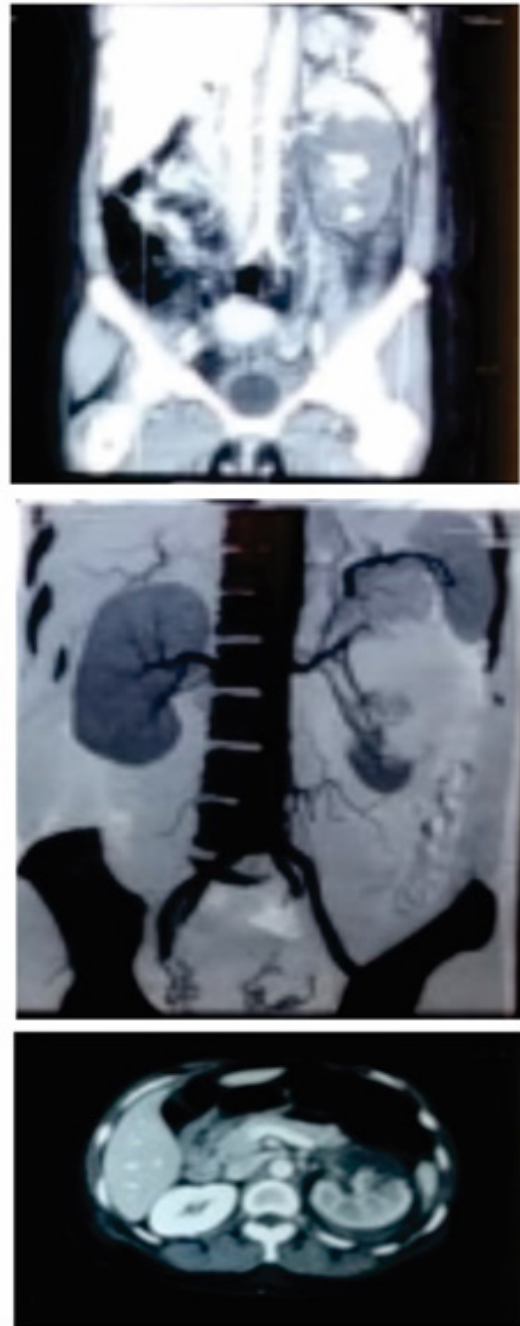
Axial and coronal contrast CT abdomen and pelvis. Grade V renal trauma was shown by the white arrow, which indicated by shattered kidney and avulsion of the renal hilum.
